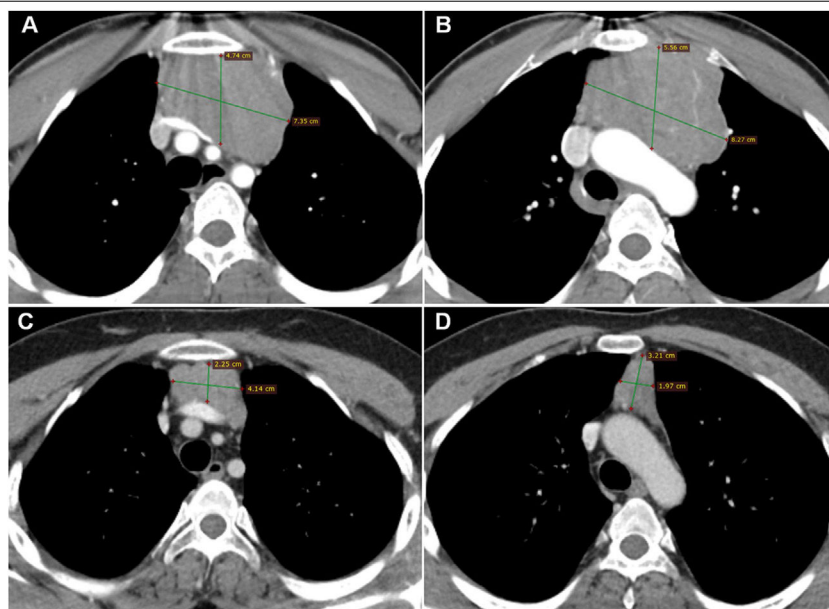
Axial sections CT of the thorax, with mediastinal window show thymoma with the anterior mediastinal location (A, B). After one month of myasthenia gravis treatment, serious regression is seen in thymoma (C, D).
